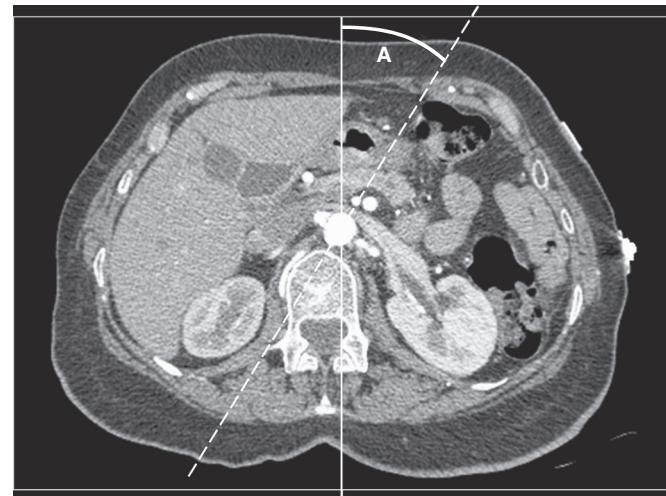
Oblique Orientation of Proximal Renal Arteries. Computed tomographic angiography demonstrates the axis perpendicular to the proximal renal arteries (dashed line) relative to the axis perpendicular to straight anteroposterior imaging (solid line). The resulting angle (*A*) indicates the oblique correction needed to avoid artifact resulting from contrast overlap between the aorta and the proximal renal artery, which could result in underestimation of the degree of renal artery stenosis.
